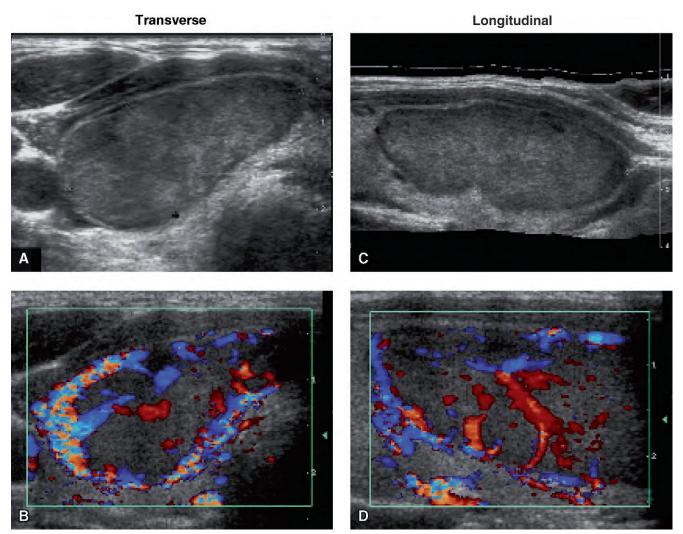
Ultrasound of follicular adenoma in the right lobe and isthmus. A, Transverse, 14 x 29 mm. B, Color Doppler, transverse, 15 x 36 mm. C, Longitudinal. D, Color Doppler, longitudinal.
